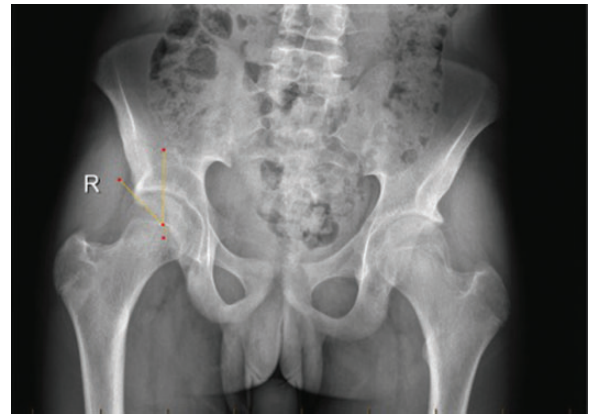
Measurement of the center-edge angle on anterior-posterior pelvis radiograph. The yellow lines depict the angle subtended between a vertical line through the center of the femoral head and a line extending to the lateral edge of the sourcil. R, right.
